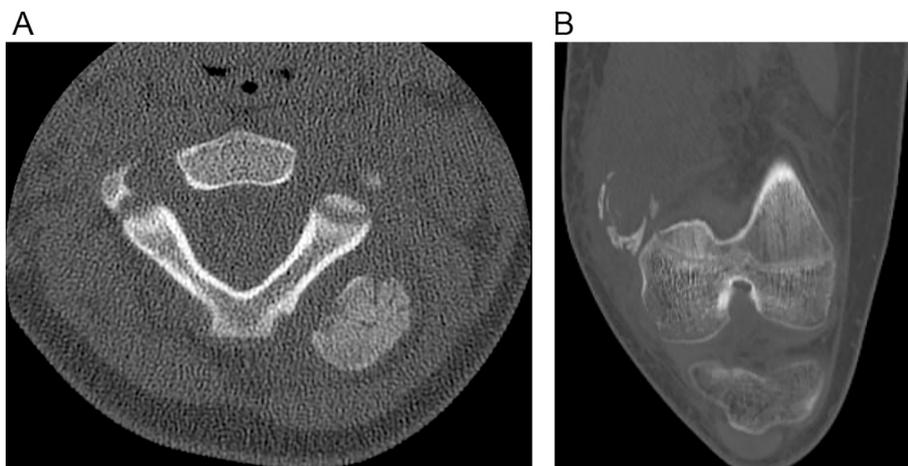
Axial CT of the cervical spine and coronal CT of the knees both performed without contrast highlighting the typical imaging appearance of myositis ossificans in two separate patients. Ossifications are usually peripheral and centripetal. Hence, the margins are dense with decreased (A) or absent ossification centrally (B).
